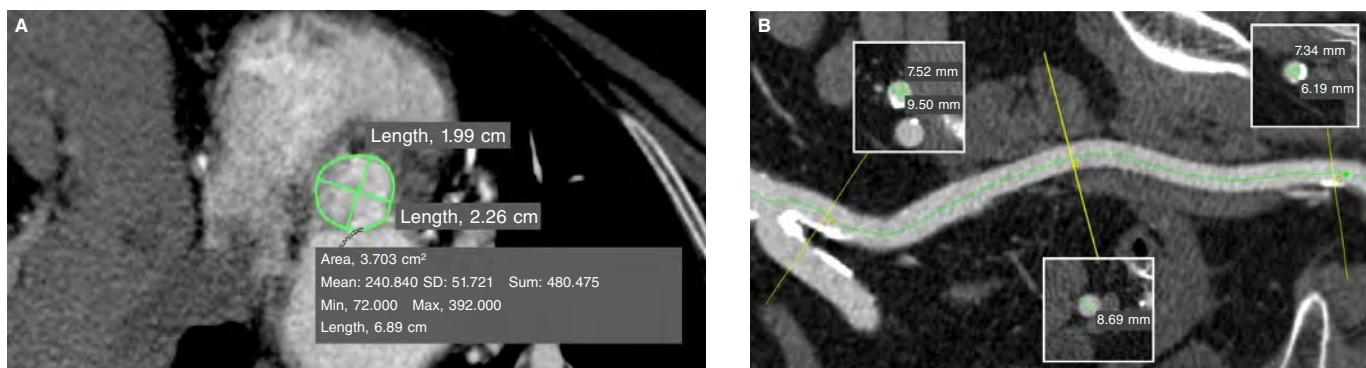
Computed tomography angiography prior to the procedure. A: measurements of the aortic valve ring: minimum diameter, 1.99 cm; maximum diameter, 2.26 cm; perimeter, 6.89 cm; area-derived perimeter, 3.70 cm². B: measurements of the left iliac-femoral axis: minimum diameter of the common femoral artery, 6.19 mm; minimum diameter of the external iliac artery, 8.69 mm; minimum diameter of the primitive iliac artery, 7.52 mm. M, mean; max, maximum; min, minimum; s, sum; SD, standard deviation.
